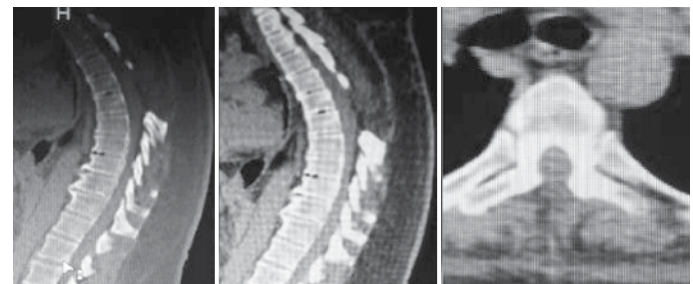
Post-operative CT, sagittal and axial sections.
